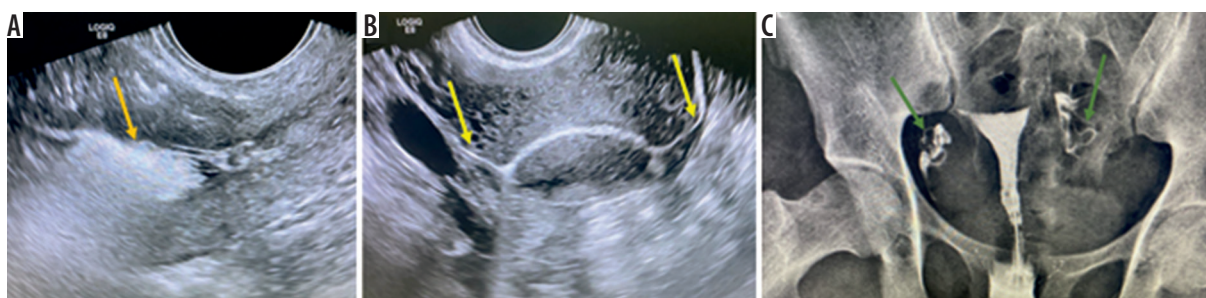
Transvaginal ultrasound images after injection of the foam into the uterus. A) Echogenic foam material outlining the endometrial cavity (orange arrow). B) Spillage of ultrasonic contrast in both patent tubes (yellow arrows). C) Hysterosalpingography of the same patient showing patency of both tubes (green arrows)
